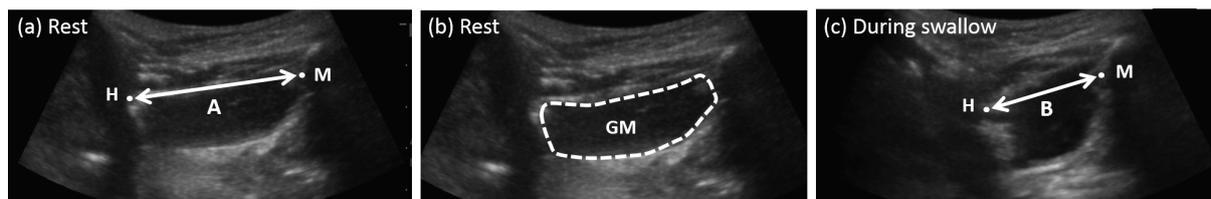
Submental ultrasonic still images: (a), (b) at rest and (c) at maximum geniohyoid muscle contraction. The images show: measurement landmarks in the regions of the surface layer attachment of the geniohyoid muscle to the hyoid bone (H) and mandible (M); the distance between these two points, taken as the length of the geniohyoid muscle at rest (A) and at maximum contraction (B); and the area of geniohyoid muscle at rest, as the region (dashed line) enclosing the muscle and fascial membrane boundary. H, hyoid bone; M, mandible; GM, geniohyoid muscle.
